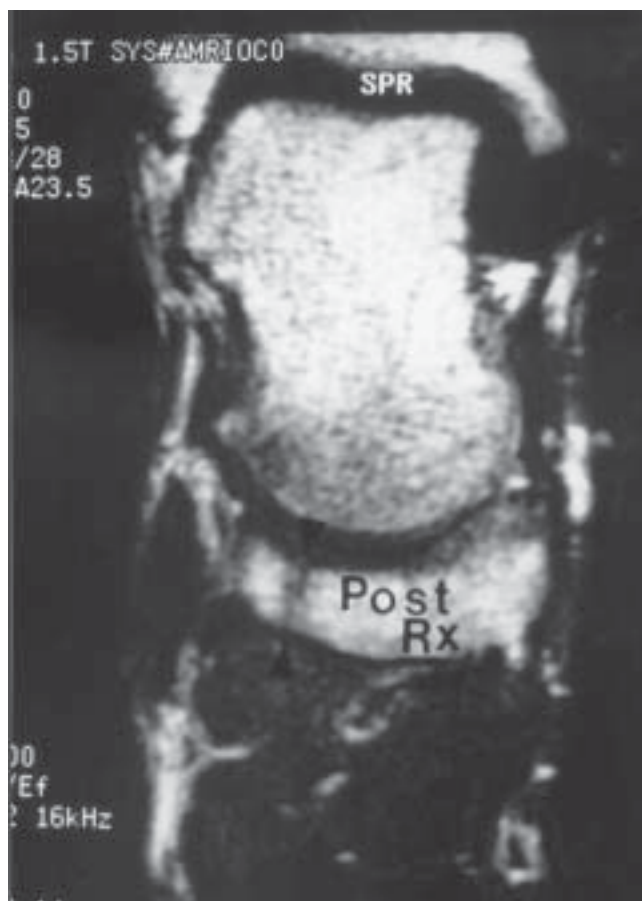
This is the post treatment MRI from 1/27/98, which was obtained before he was allowed to return to competitive basketball. The fracture line appears less distinct, not as long and the articular margins appear to show consolidation of the fracture line. This is the coronal view, which is similar to the view from Figure 2.
